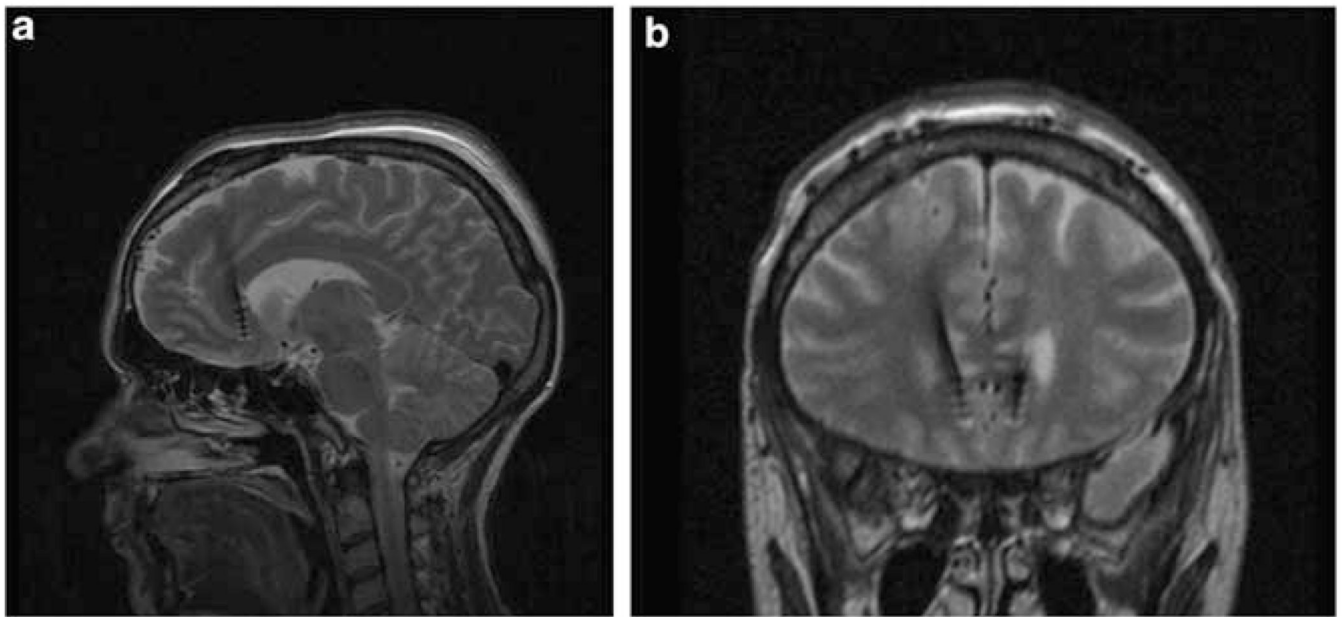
Postoperative magnetic resonance imaging (MRI). Sagittal (a) and coronal (b) slice of a postoperative T2-weighted structural MRI with electrodes at CG25 target area (case 1).
